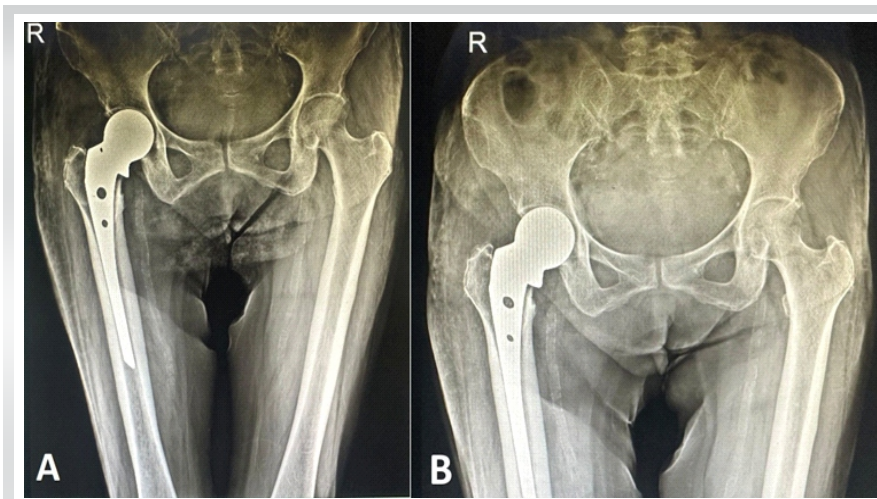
(a) Immediate post-operative radiograph, (b) radiograph at 6 months of follow-up.
